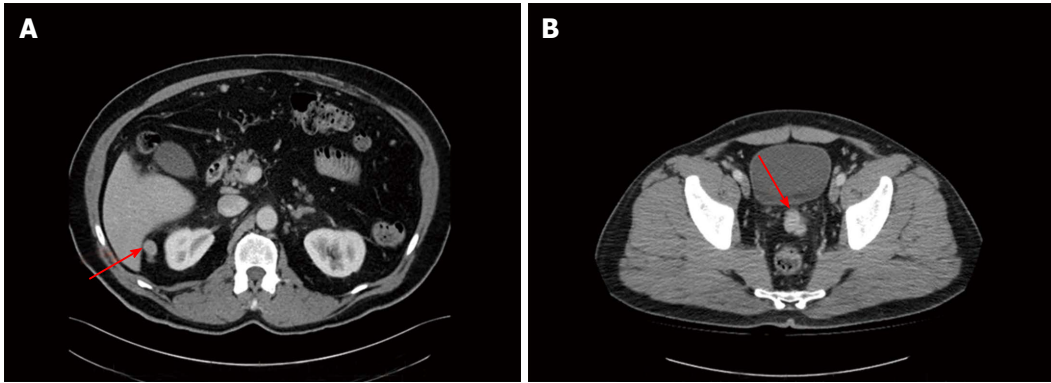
Axial computed tomography image of the abdomen. A: Red arrow pointing to soft tissue mass in between liver and right kidney; B: Red arrow pointing to soft tissue mass between bladder and rectum.
